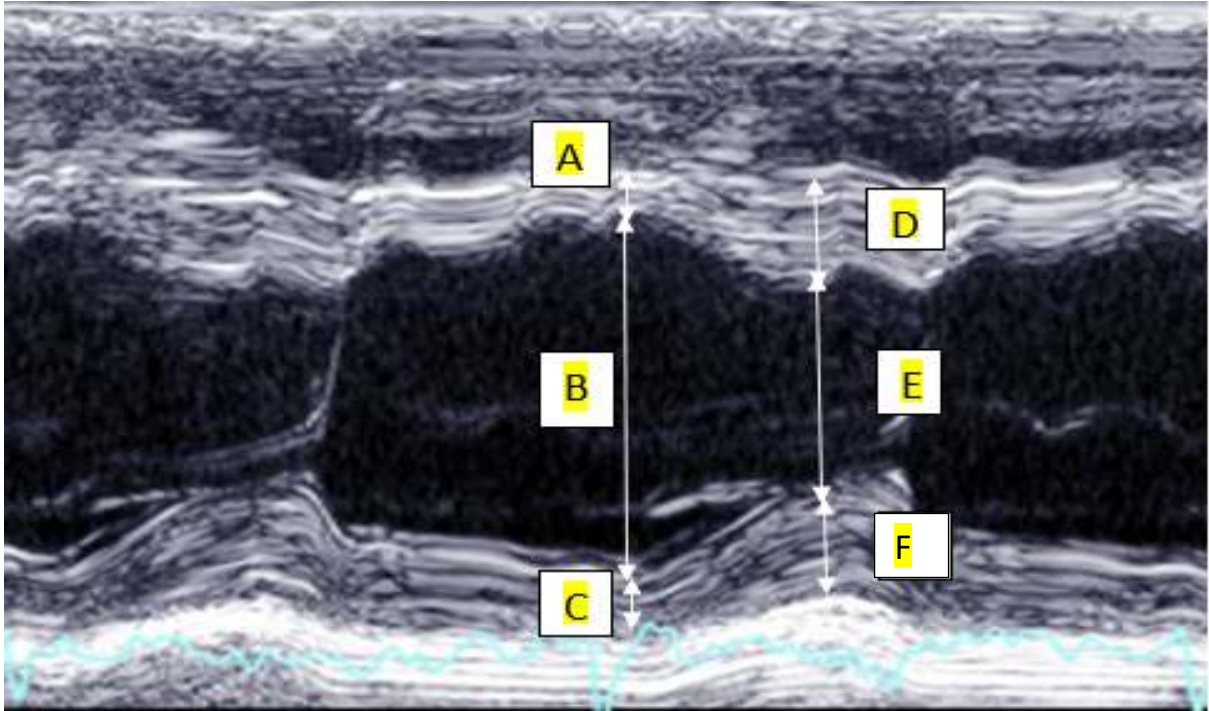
Two-Dimensional M-mode guided echocardiographic view. A is the interventricular septal wall thickness in diastole (IVSd), B is the left ventricular inner diameter in diastole (LVIDd), C is the left ventricular posterior wall thickness in diastole (LVPWd), D is the interventricular septal wall thickness in systole (IVSs), E is the left ventricular inner diameter in systole (LVIDs), F is the left ventricular posterior wall thickness in systole (LVPWs).
